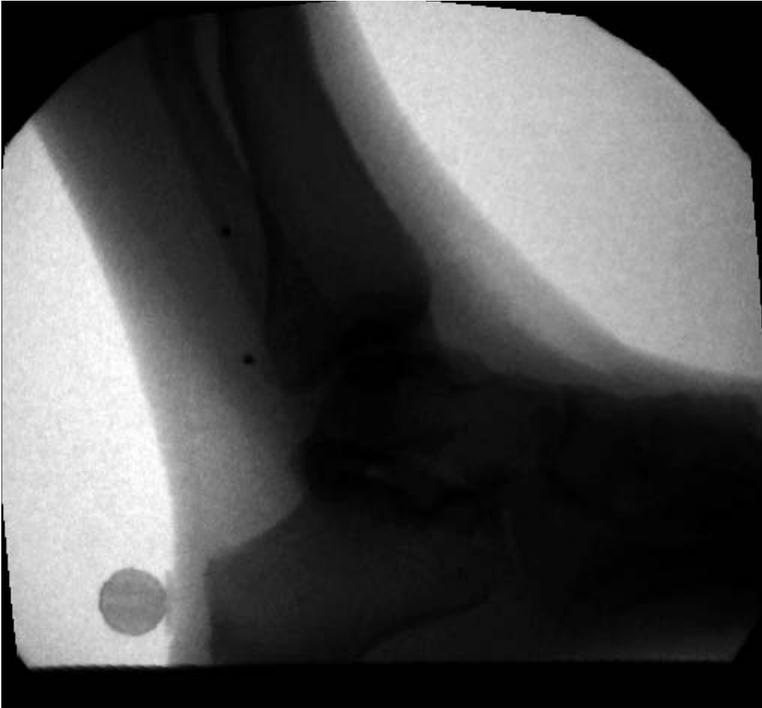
Single plane fluoroscopic X-ray image of ankle joint complex (Image courtesy of Ben McHenry, Marquette University).
